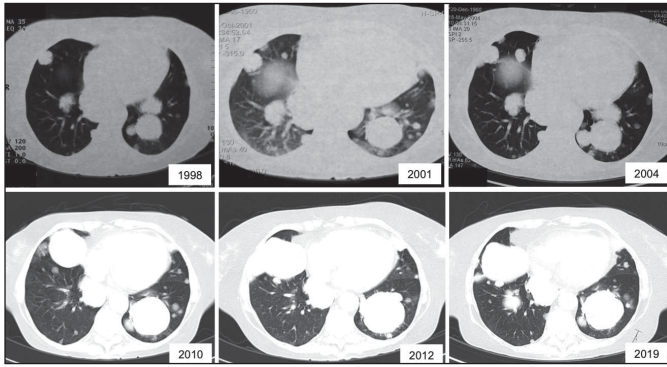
CT scans showing the indolent progression of lung metastases.
